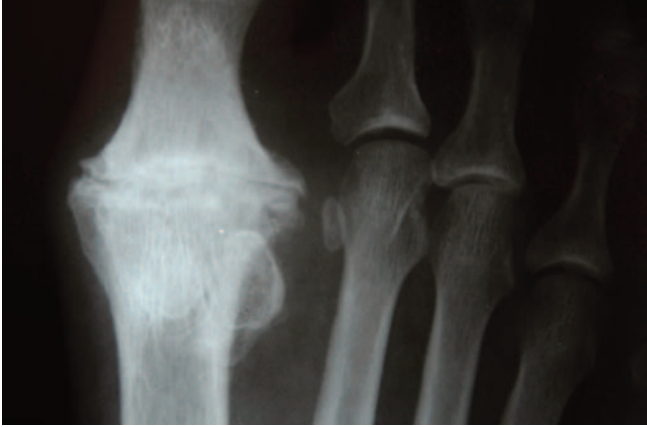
Case Study 1. Preoperative AP radiograph.
